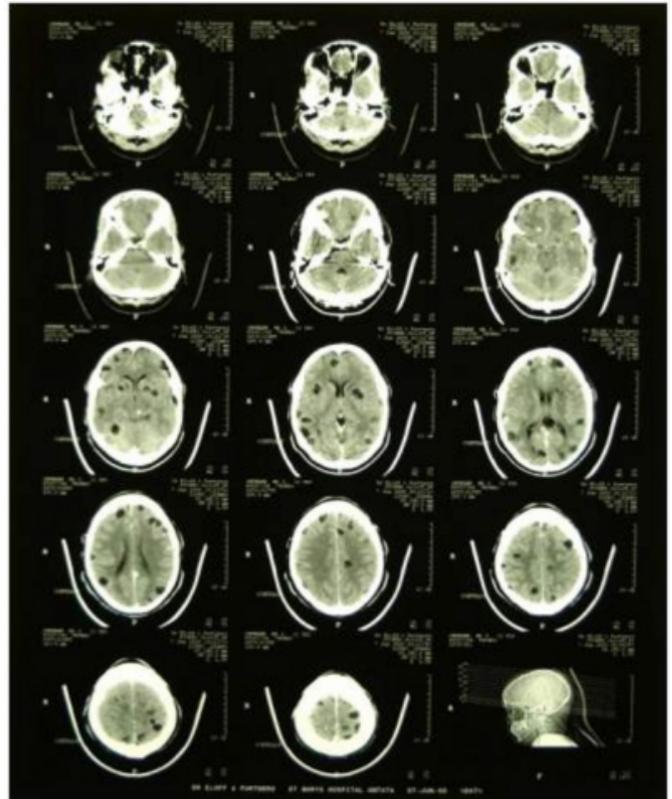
Cystic lesions showing the scolex on CT brain scan.
